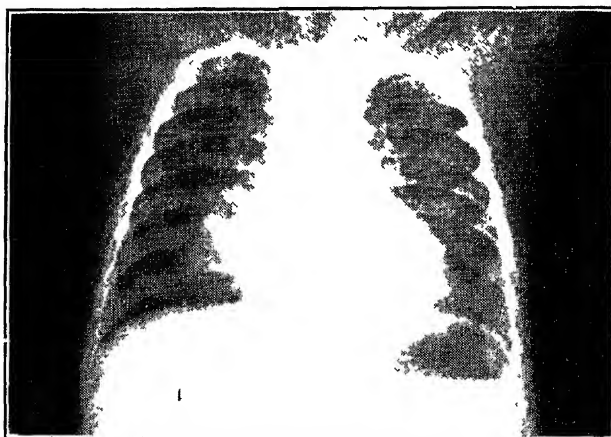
Roentgenogram taken 7-29-'32 Shows exudative lesion in right hilus region extending into right base (Mitchell and Nelson *Ohio State M J*)
